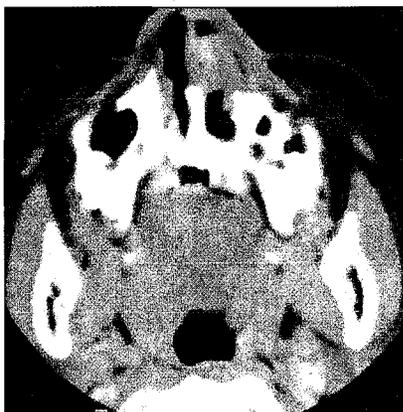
Axial CT scan of Case 1 showing a localized tumor arising from the septum and obstructing the nasal cavity.
